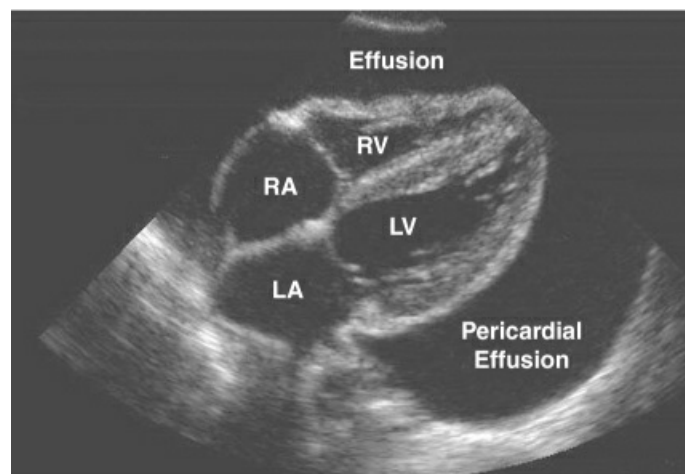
Ultrasound image (subcostal view) showing a large pericardial effusion, which appears as a broad anechoic band surrounding the heart. Image retouched from Loyola University Stritch School of Medicine, medical education curriculum in radiology, at www.stritch.luc.edu, accessed 11/18/2023.
